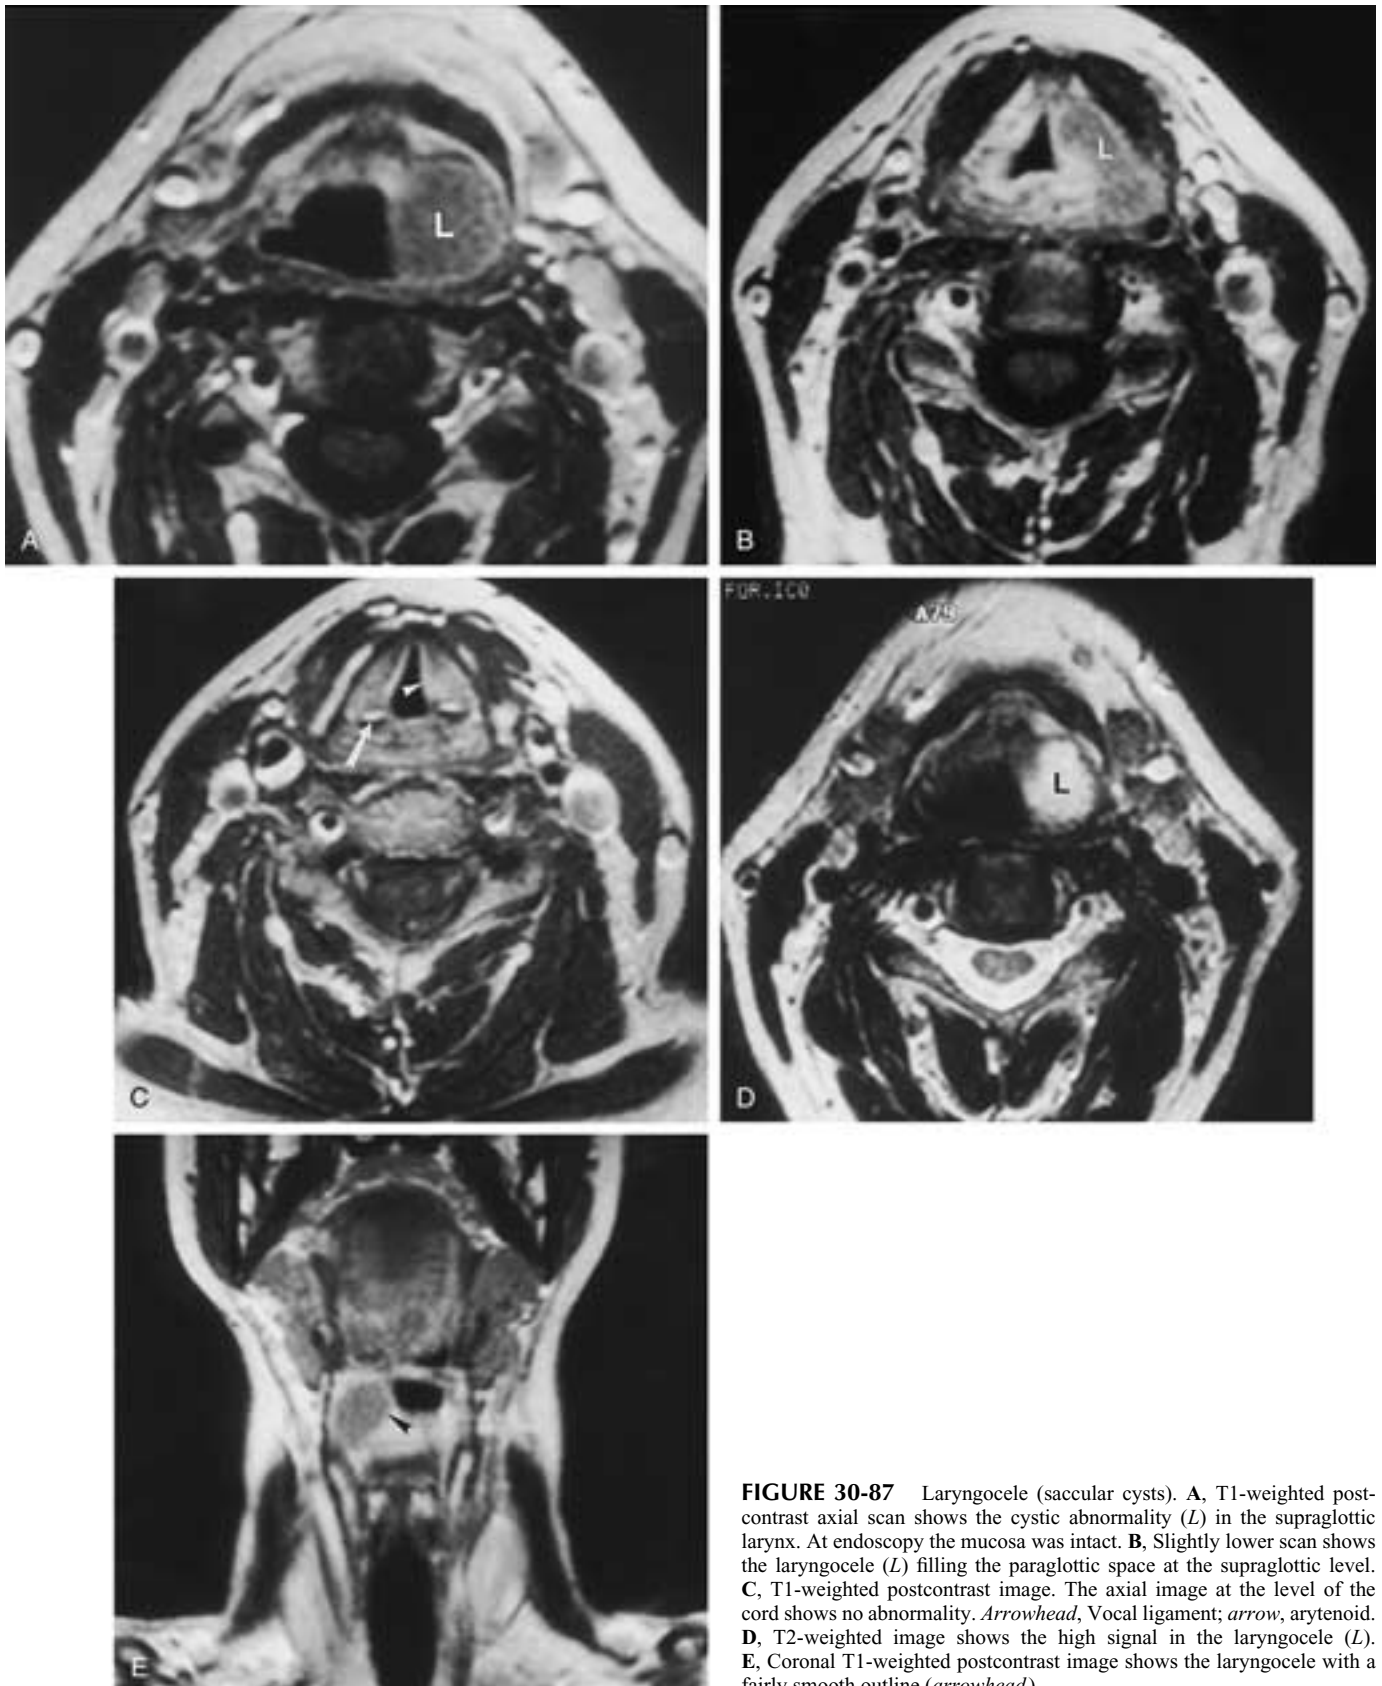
Laryngocele (saccular cysts). A, T1-weighted post-contrast axial scan shows the cystic abnormality (*L*) in the supraglottic larynx. At endoscopy the mucosa was intact. B, Slightly lower scan shows the laryngocele (*L*) filling the paraglottic space at the supraglottic level. C, T1-weighted postcontrast image. The axial image at the level of the cord shows no abnormality. *Arrowhead*, Vocal ligament; *arrow*, arytenoid. D, T2-weighted image shows the high signal in the laryngocele (*L*). E, Coronal T1-weighted postcontrast image shows the laryngocele with a fairly smooth outline (*arrowhead*).
